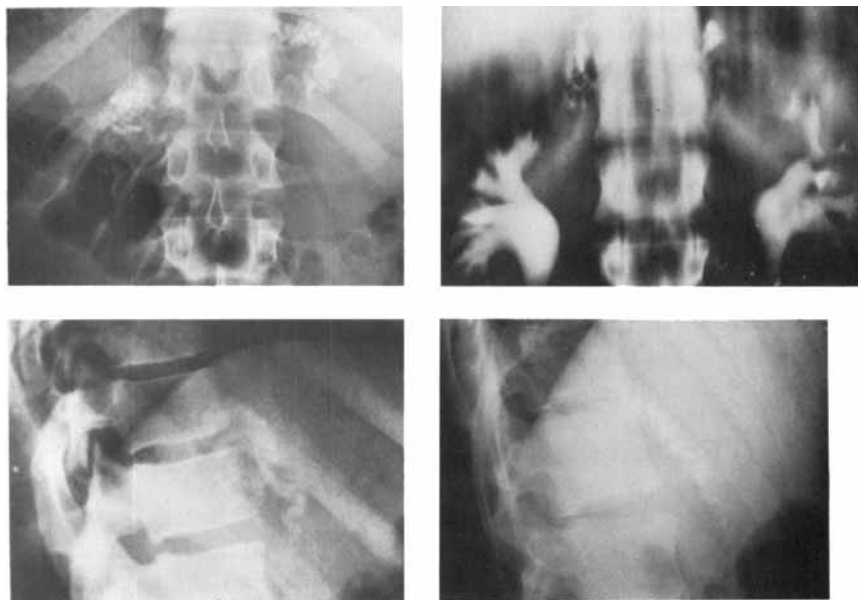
The X-ray appearance of adrenal calcification in two adult males. Both antero-posterior and lateral films are shown for patient 1 (left) and patient 2 (right). The film for patient 2 was obtained during intravenous pyelography.
